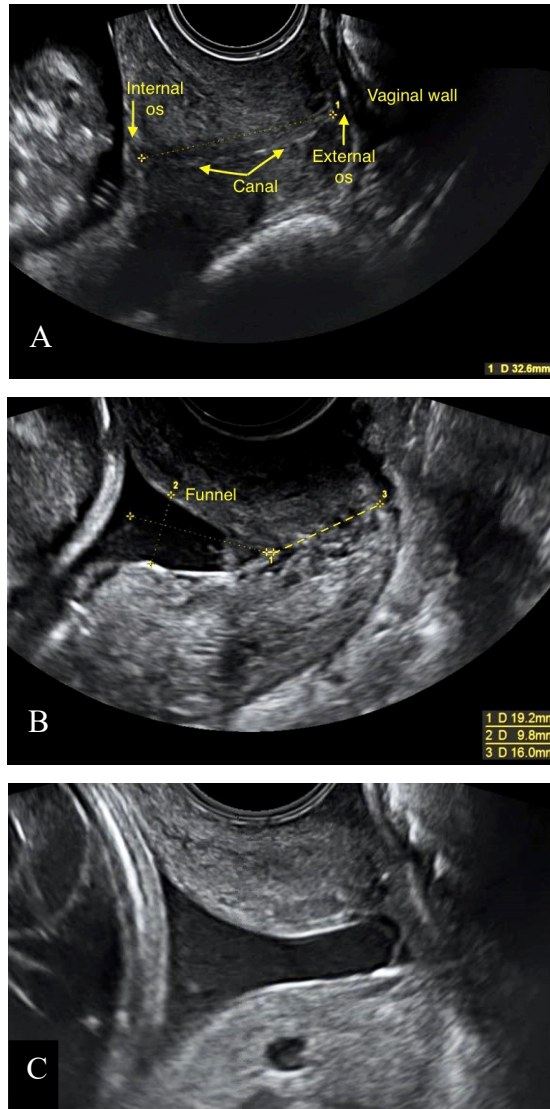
Transvaginal ultrasound assessment of cervical length. A. Normal cervical length. B. Presence of cervical funneling and prolapse of the membranes through a dilated endocervical canal. Short cervical length. C. Presence of cervical funneling and prolapse of the membranes at the level of external cervical os.
